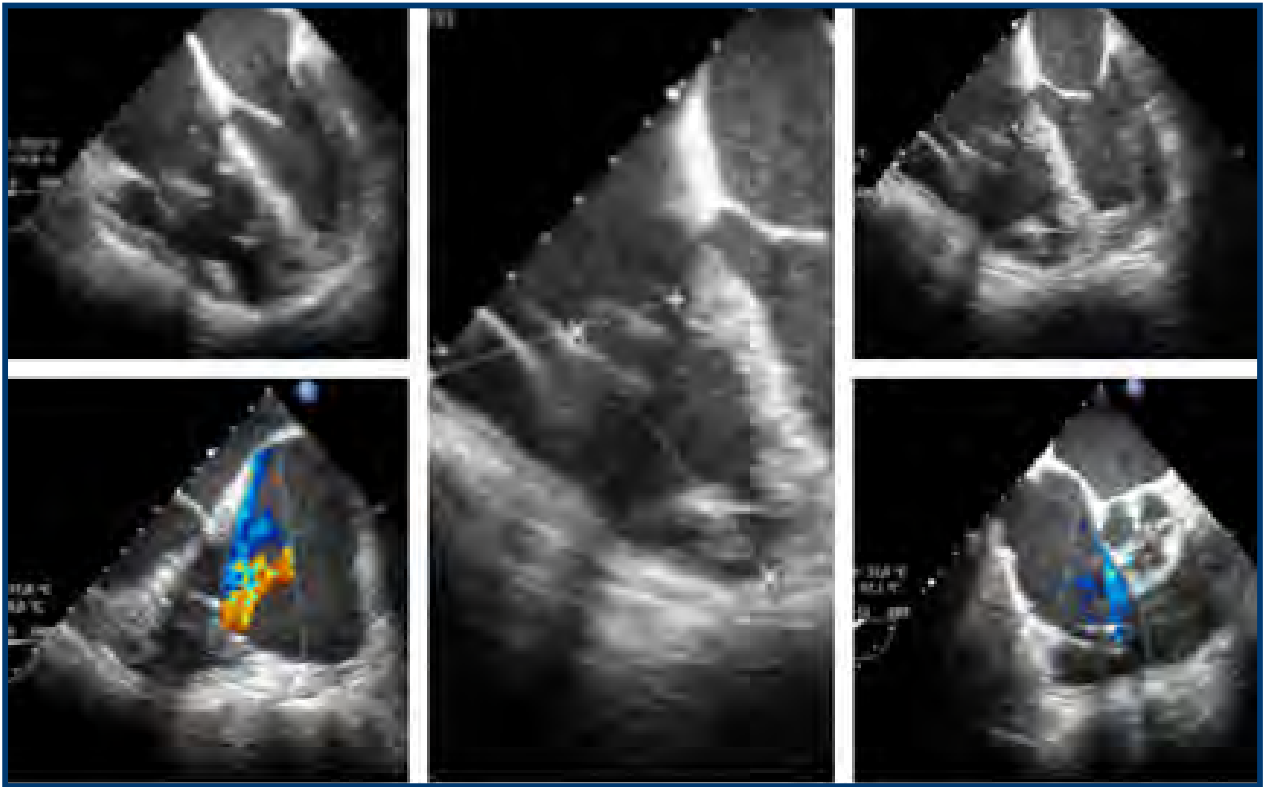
Transesophageal echocardiogram showing hyperechoic image at the level of the tricuspid valvular plane, which generates moderate-severe insufficiency.
